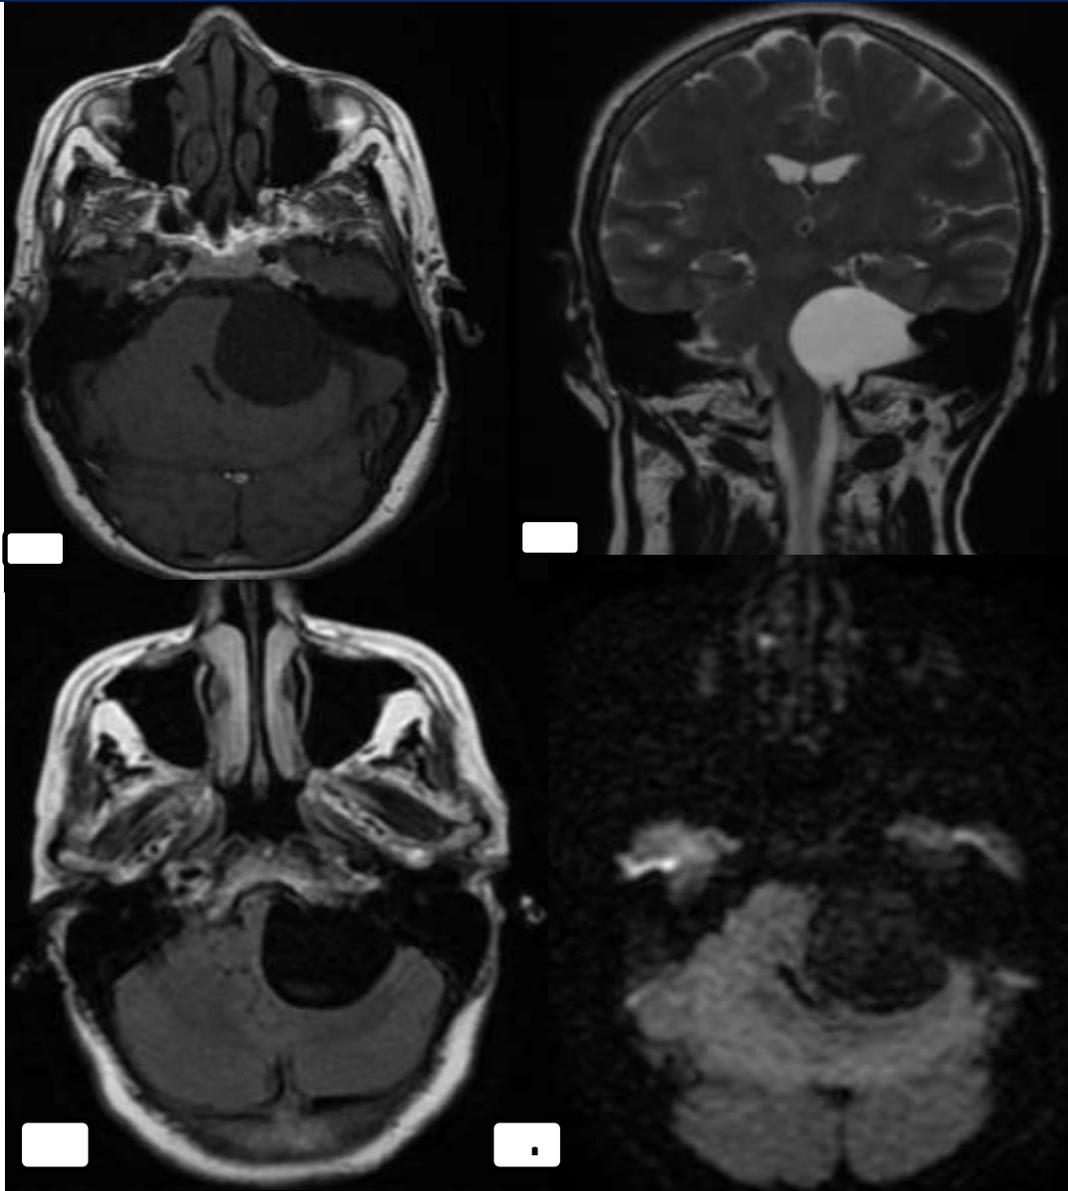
MRI in axial section in T1 sequences (a); in coronal section in T2 sequence (b); in axial section in FLAIR sequence (c) and in Diffusion sequence(d); Extra-axial cystic formation at the level of the left cerebellopontine angle, with a liquid signal that cancels out on the Flair sequence, not restrictive in diffusion.
